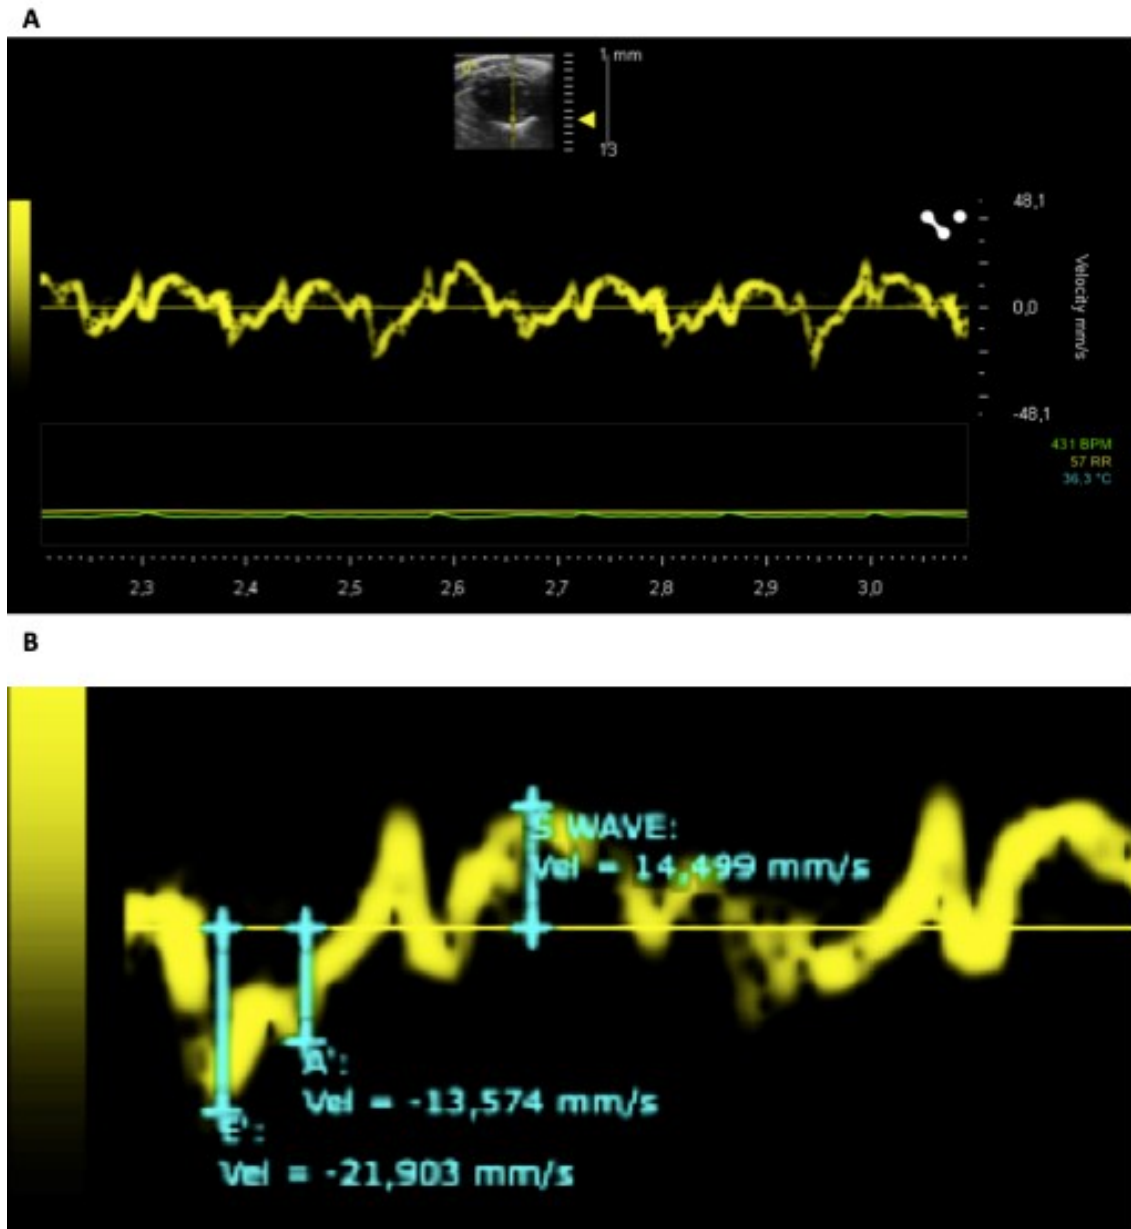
Pulsed wave tissue Doppler
